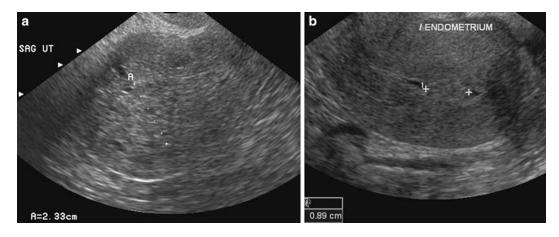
Transvaginal ultrasound of abnormally thickened endometrium. Sagittal images of the uterus demonstrate diffuse (a) and focal (b) endometrial thickening (calipers) pathologically confirmed to be endometrial cancer and a benign endometrial polyp respectively
